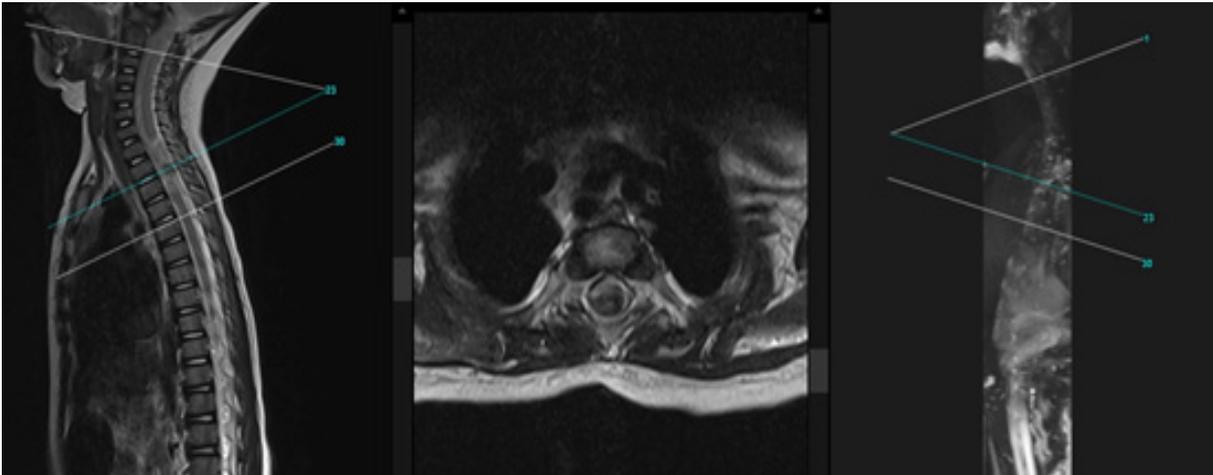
Thoracolumbar MRI
